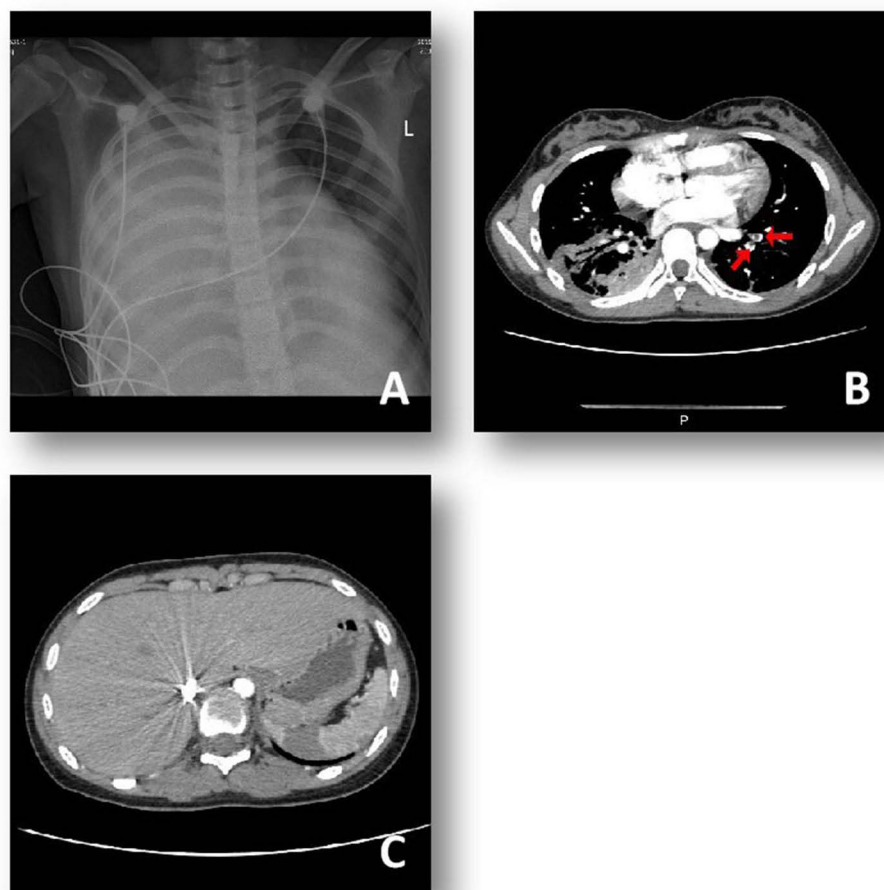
Chest X-ray showed right side pneumonia (A) Chest CTA showed a filling defect (red arrow) in the left lower pulmonary artery (B) Abdominal enhanced CT shows partial non-enhancement of the spleen, suggestive of splenic infarction (C).
